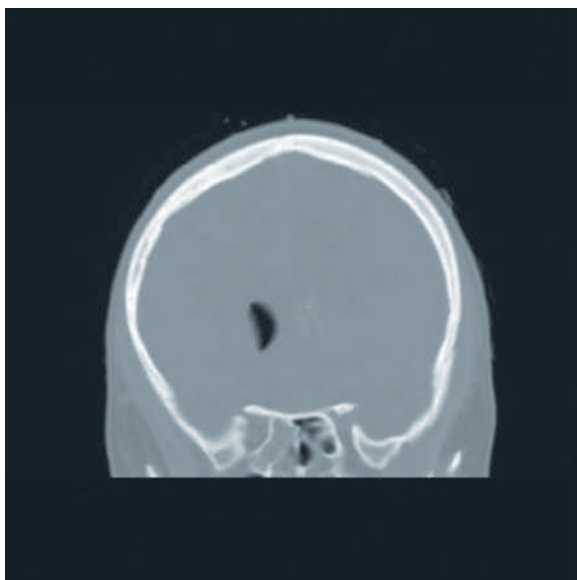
Findings consistent with a bullet track are seen extending through the midportion of the brain. The track extends from the frontal bone just left of midline through the frontal lobe and left lateral ventricle, extending posteriorly just to the left lateral aspect of the falx and exiting posteriorly near the midocciput (per computed tomographic scan report).
